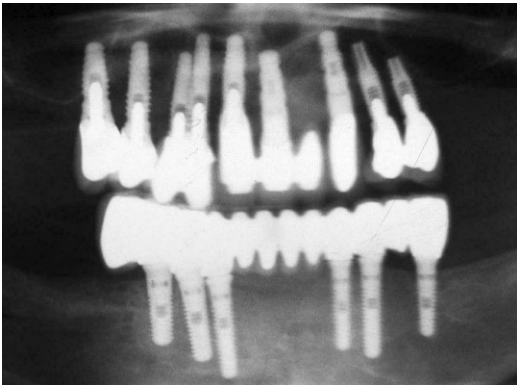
The panoramic radiograph of the bimaxillary treated patient.
